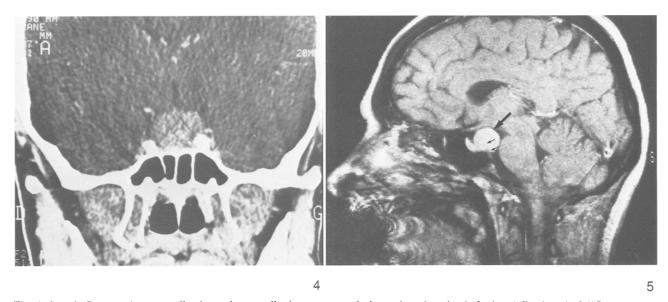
Case 2: CT scan shows a well enhanced suprasellar homogeneous lesions whose location is further defined on the MRI scan Fig. 5. Case 2: Sagittal plane Gadolinium enhanced MRI scan showing a tumour with uniform enhancement lying in the interpeduncular cistern (big black arrow) which explains the erosion of the dorsum sellae (double small black arrows) and confirms the chronic evolution of the lesion
